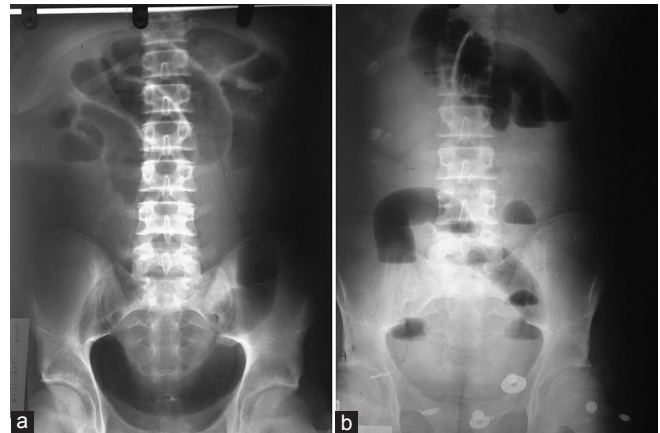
(a) Abdominal radiography supine showing distended loops of small intestine. (b) Abdominal radiography erect showing multiple air/fluid levels.
